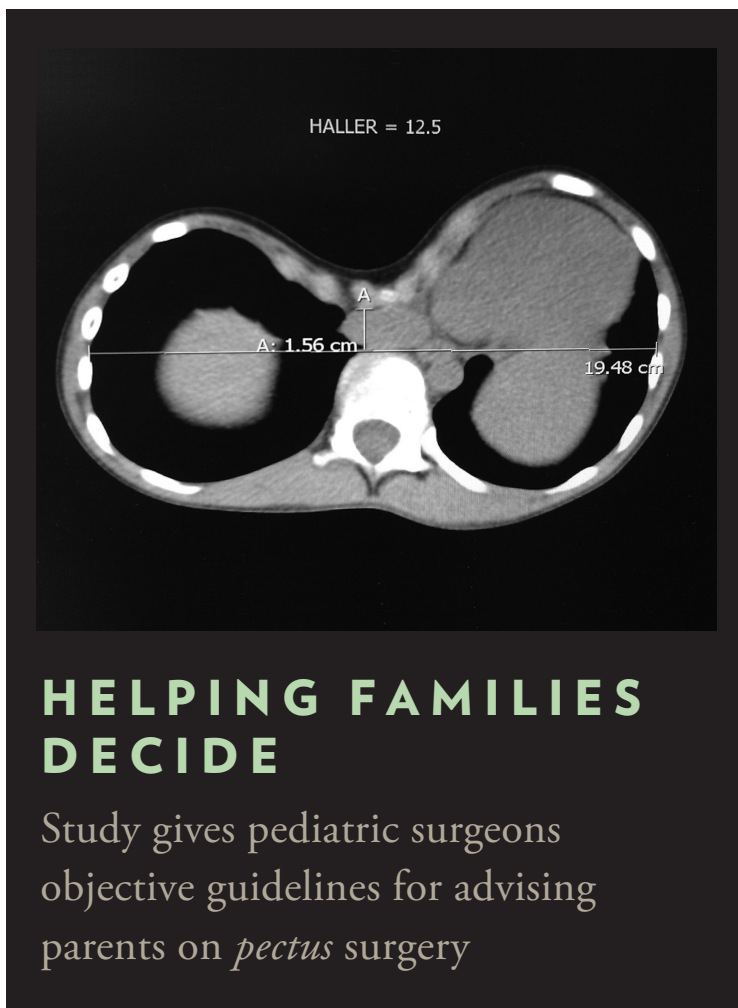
Figure left: CT scan demonstrates compression of the lungs and complete shift of the heart into the left side of the chest. The sternum is almost touching the spine.
